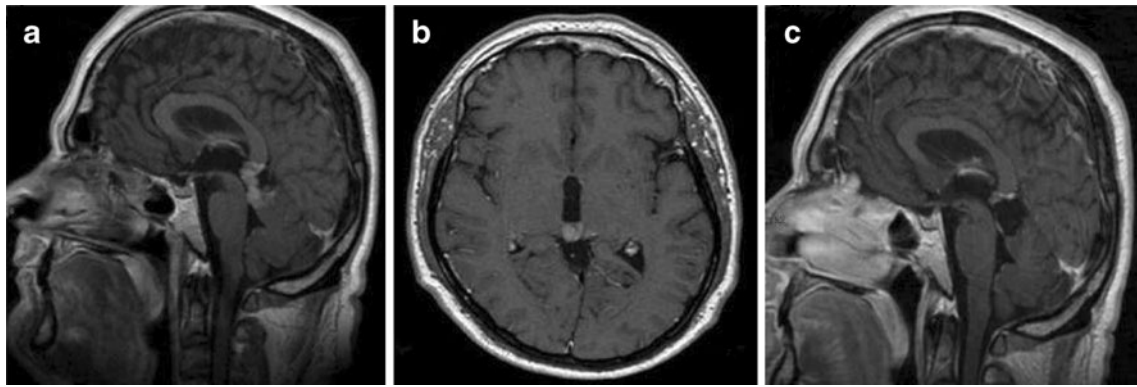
Preoperative a sagittal and b axial T1-enhanced MRI showing a posterior third ventricle PNET; c postoperative 2-year F-U sagittal T1-enhanced MRI showing the PNET complete removal
